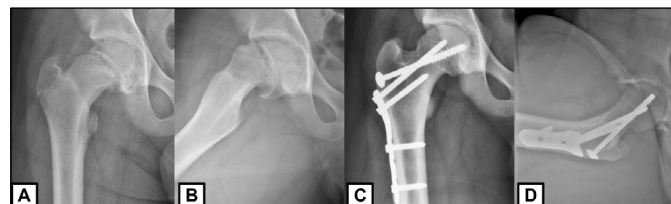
Anteroposterior and lateral radiographic images of a patient before (A and B) and two years after (C and D) osteotomy at the base of neck and osteoplasty.
